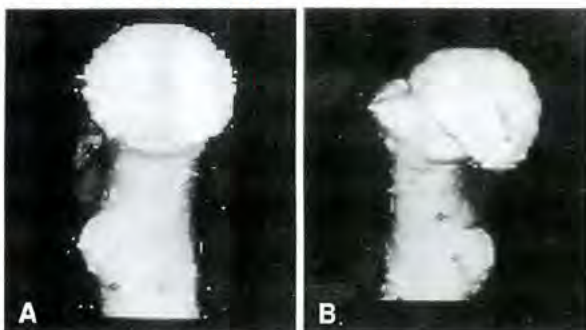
A, B : 3D-CT of SCFE (lateral view of femoral head)
